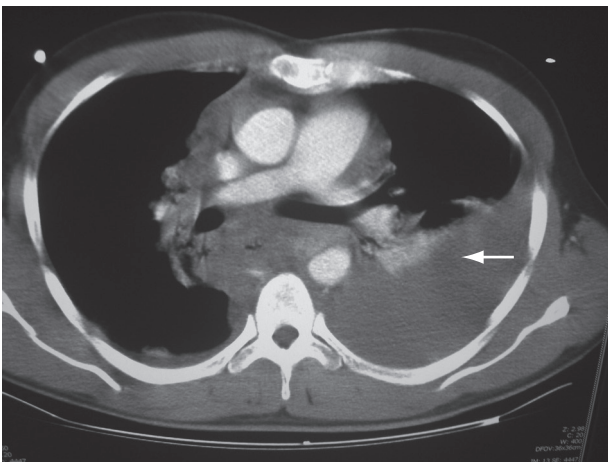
Left-sided hemothorax visible on chest computed tomography (CT) scan (arrow).
